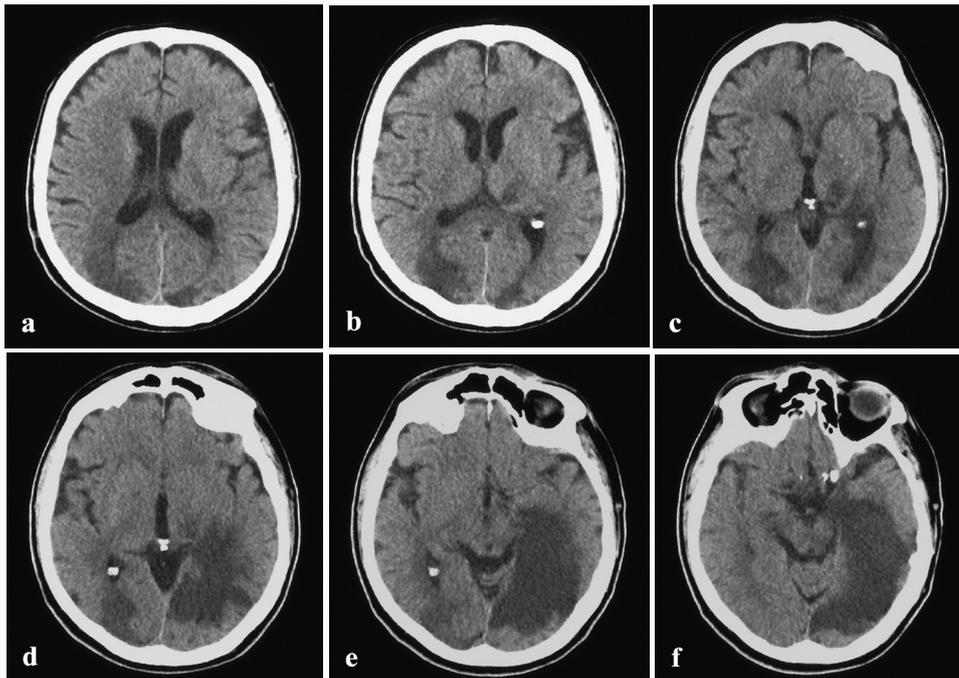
Serial axial CT scans showing an ischemic area of the right occipital lobe and a large ischemic region of the left occipital and temporal lobes.
